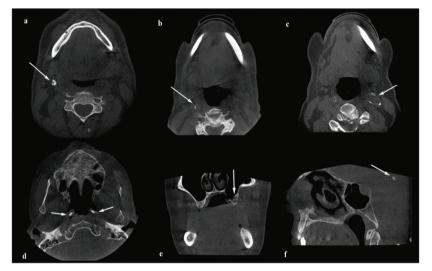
Exemplar soft tissue calcification cases are shown with arrows in cone-beam computed tomography images: a) Calcified lymph node; b) Calcified carotid artery; c) Phlebolith; d) Tubal tonsilloliths; e) Antrolith; f) Pineal gland calcification.
